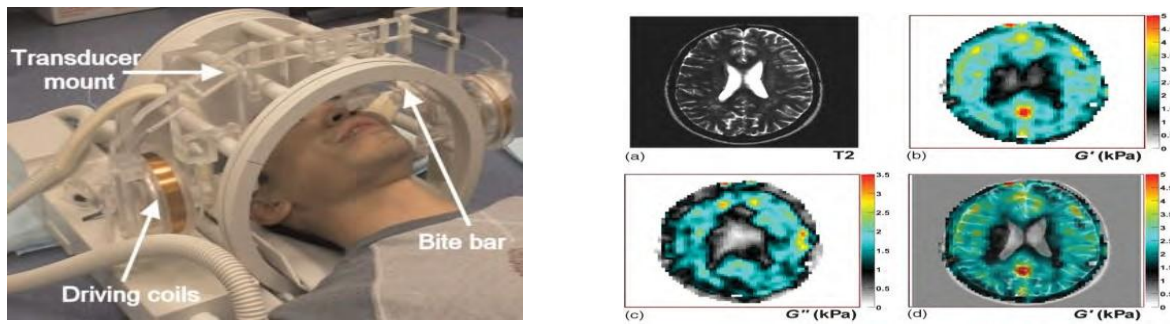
[Left] MRE set up with external vibrator, transducer mount, driving coils and bite bar. [Right] MRE in vivo image (a) T2-weighted MR image; (b) G' (kPa) image; (c) G'' (kPa) image. (d). overlapped image of b) and a).¹⁹
